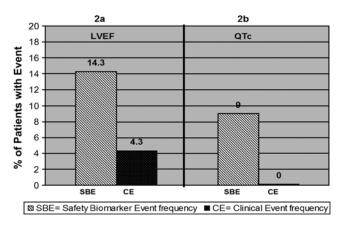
(A) Reported frequencies of abnormal left ventricular function represented by MUGA/echo and clinically evident congestive heart failure. The safety biomarker events are frequent and correlate with frequent clinical events. In such a circumstance, safety biomarker strategies in clinical studies often apply the same thresholds for eligibility, analyses, and dosing. (B) Reported frequencies of prolonged QT/QTc and associated arrhythmia. The safety biomarker events are frequent, but clinical events are rare. In this circumstance, safety biomarker strategies can reasonably apply different thresholds for eligibility, analyses, and dosing. MUGA indicates multigated acquisition scan; echo, echocardiography; QT/QTc, heart rate corrected QT; LVEF, left ventricular ejection fraction; SBE, safety biomarker event frequency; CE, clinical event frequency.
